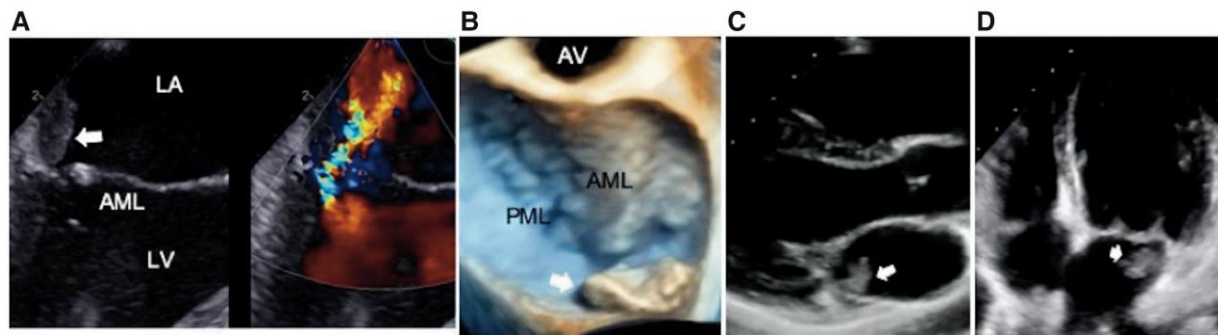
(A) Transoesophageal echocardiography revealed that the vegetation was located at the posterior wall, which was exposed to an eccentric mitral regurgitation jet. (B) Three-dimensional images showed the morphology of the vegetation and its attachment to the posterior wall. (C) Transthoracic echocardiography during follow-up (arrows) in the parasternal long-axis view. (D) Transthoracic echocardiography during follow-up (arrows) in the apical four-chamber view. LA, left atrium; LV, left ventricle; AV, aortic valve; AML, anterior mitral leaflet; PML, posterior mitral leaflet.
